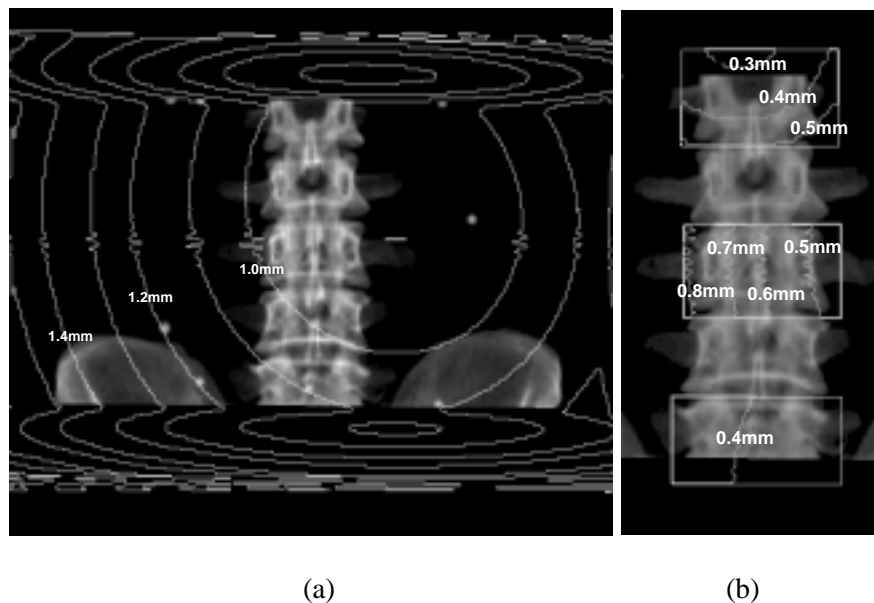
Contoured plots of $\overline{d(u, v)}$ over a DRR produced using the “gold-standard” parameters; (a) shows $\overline{d(u, v)}$ over the entire CT volume and DRR; (b) shows $\overline{d(u, v)}$ over the reduced CT volumes and ROI for the L1, L3 and L5 vertebrae. The outer contour in (b) is the limit of the fields of view drawn around each vertebra.
